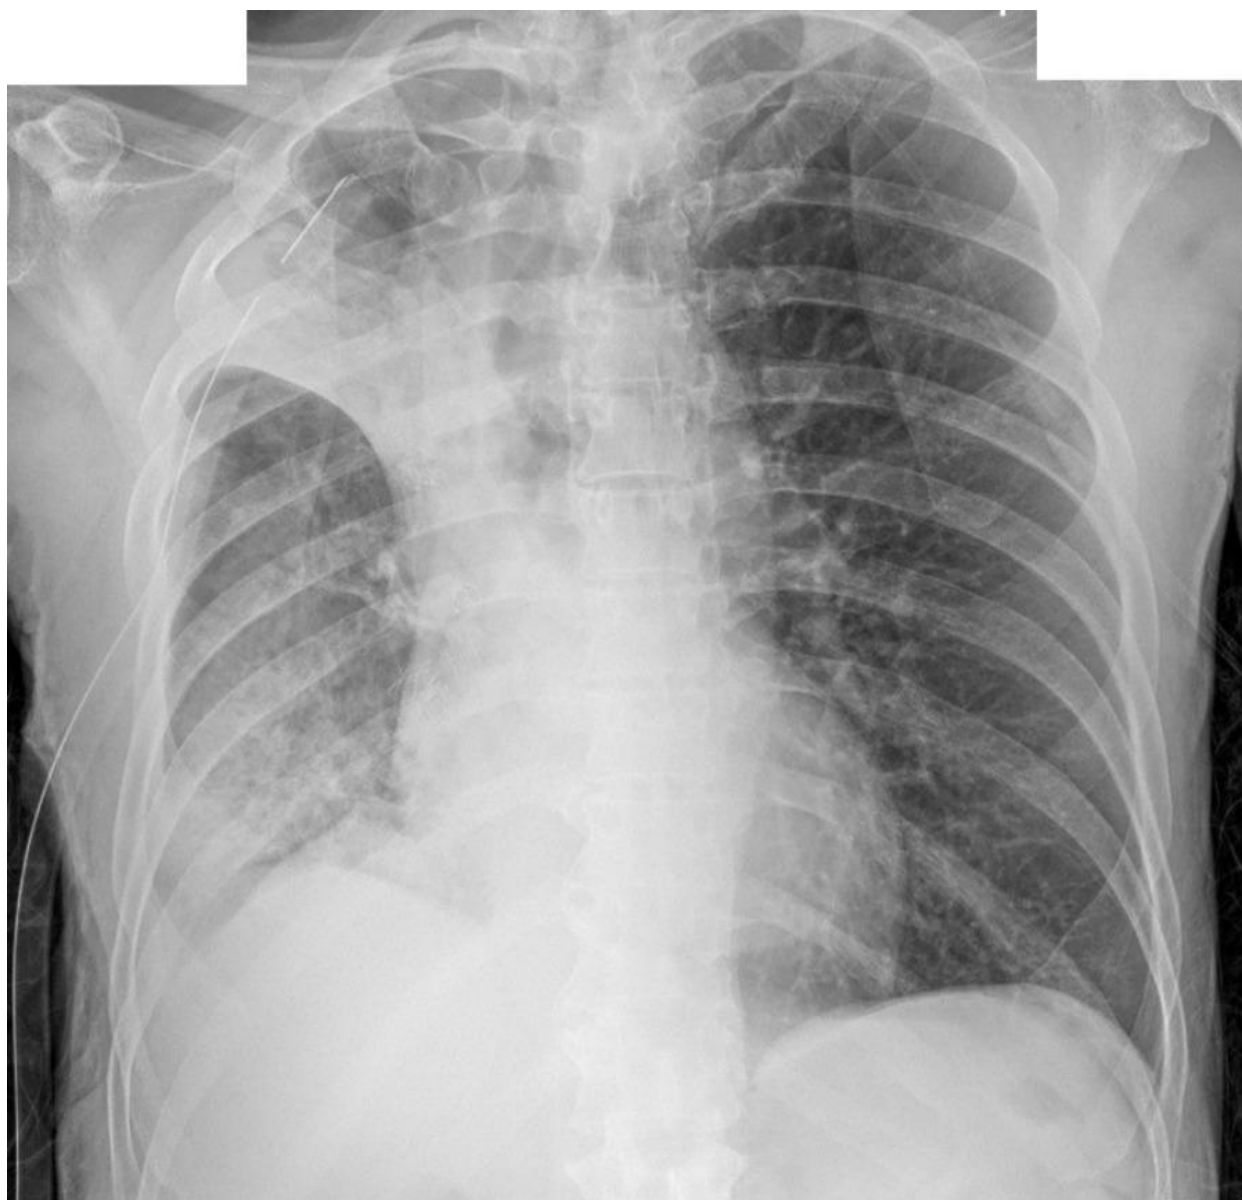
Chest radiograph showing good expansion of the right lung post-second EBV insertion with right upper lobe collapse
